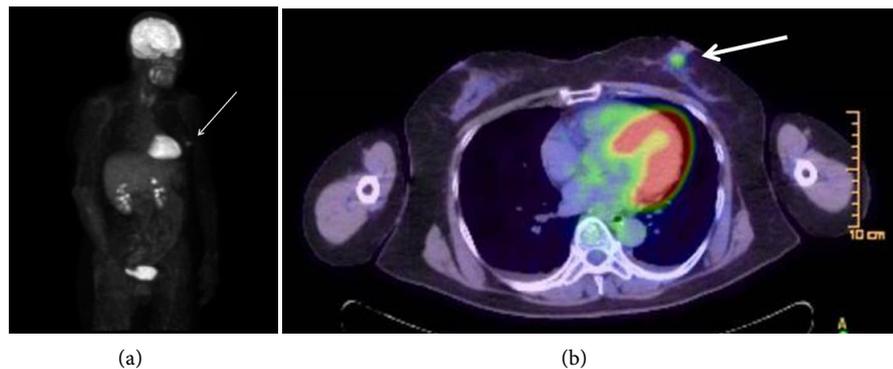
A 64-year-old woman with luminal A invasive ductal cancer (14 mm; ER 90%, PR 70% HER2 0, Ki-67 1%, nuclear grade 1, T1cN0M0). (a) ^{18}F -FDG PET MIP image. (b) Axial PET/CT image. SUVmax value was 3.2.
